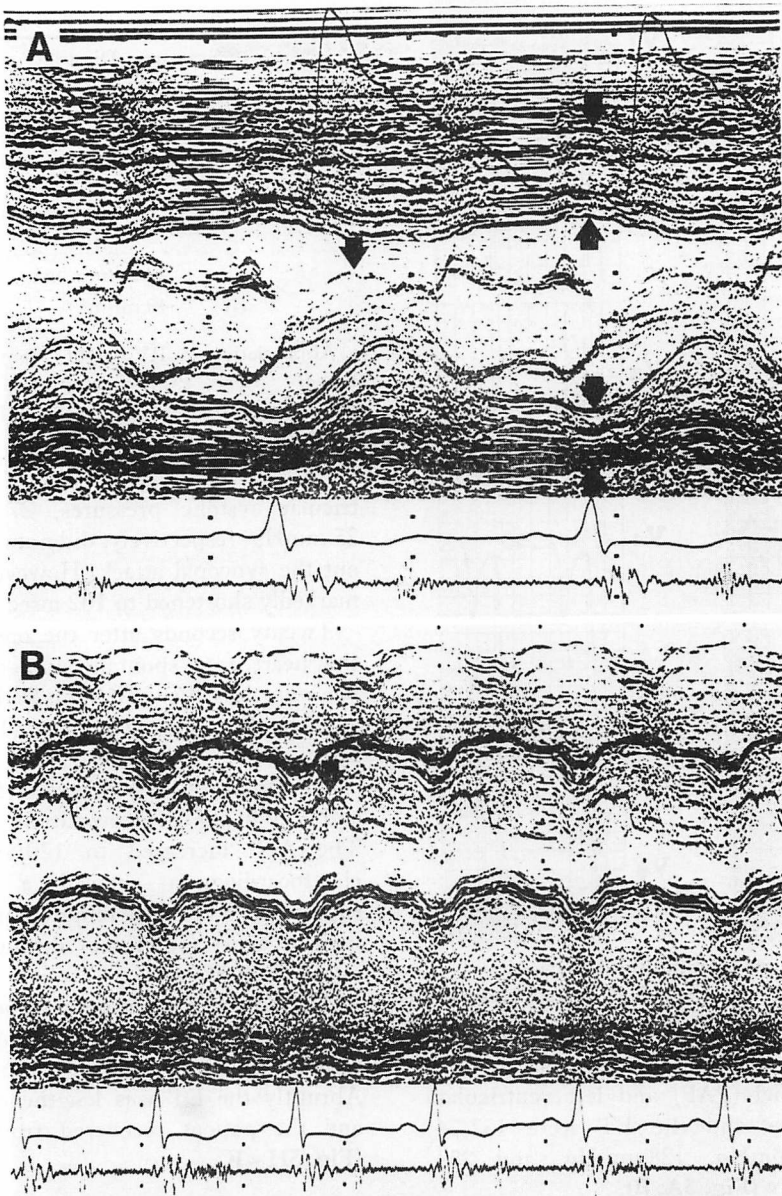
M-mode echocardiograms.
